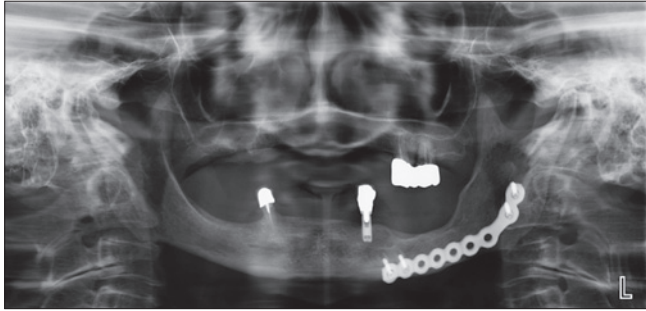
Postoperative panoramic radiograph (at 24 months) showing the stable position of the reconstructive plate and extraordinary regrowth of mandibular bone.
